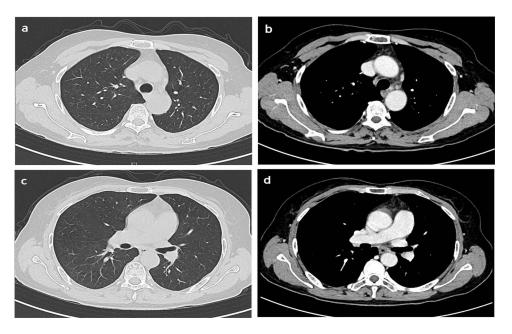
After more than I month of the treatment, the follow-up chest CT exhibited reduced mediastinal (a and b) and hilar (c and d) lymph nodes relative to that before the treatment.
